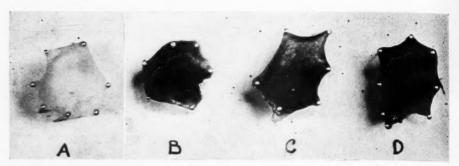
Typical changes in and gross appearance of the gall bladder after exposure to X-rays. A, the appearance of the normal mucosa; B, C, and D, extensive gross changes manifested by changes in thickness and color.
